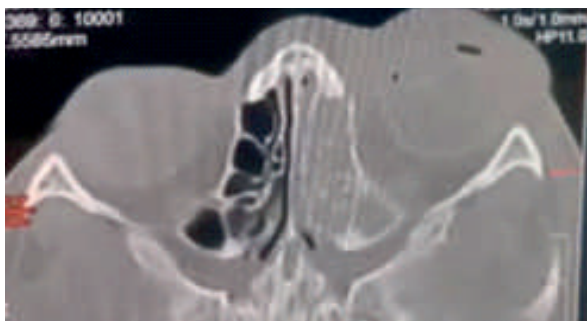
Axial section of bony window of computed tomogram scan showing ethmoid sinusitis with pre-septal cellulitis.
